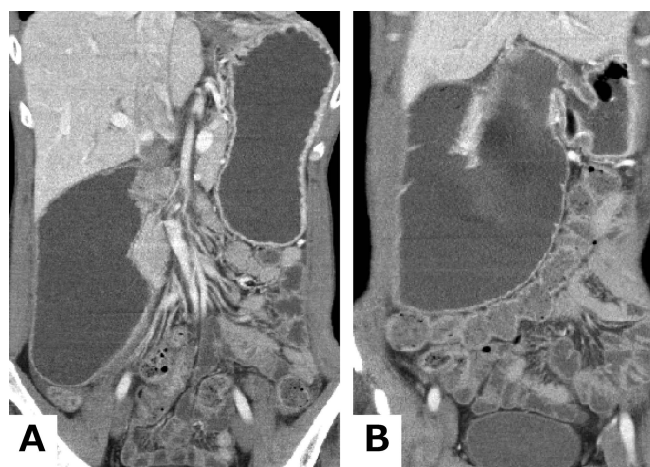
Enhanced CT during first admission. A. Duodenal stricture and dilatation of the stomach and duodenum. B. Colon positioned from the right side to the left side in the abdominal cavity.
